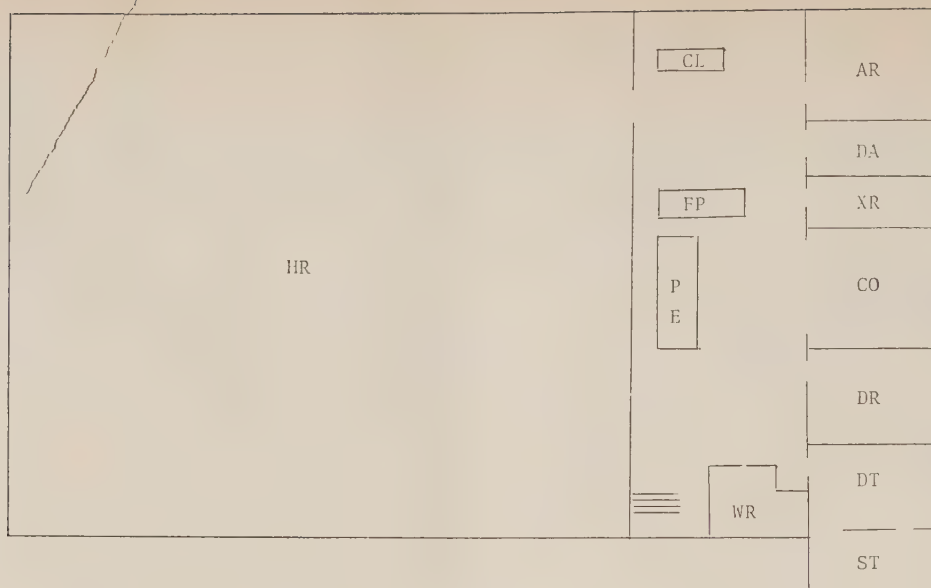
Floor plan of morgue. HR hockey rink, CL control of labelling, AR autopsy room, DA dark room, XR x-ray room, CO coordinating office, DR dressing room, DT dental team, ST storage room, FP fingerprint, PE personal effects, WR workroom.
